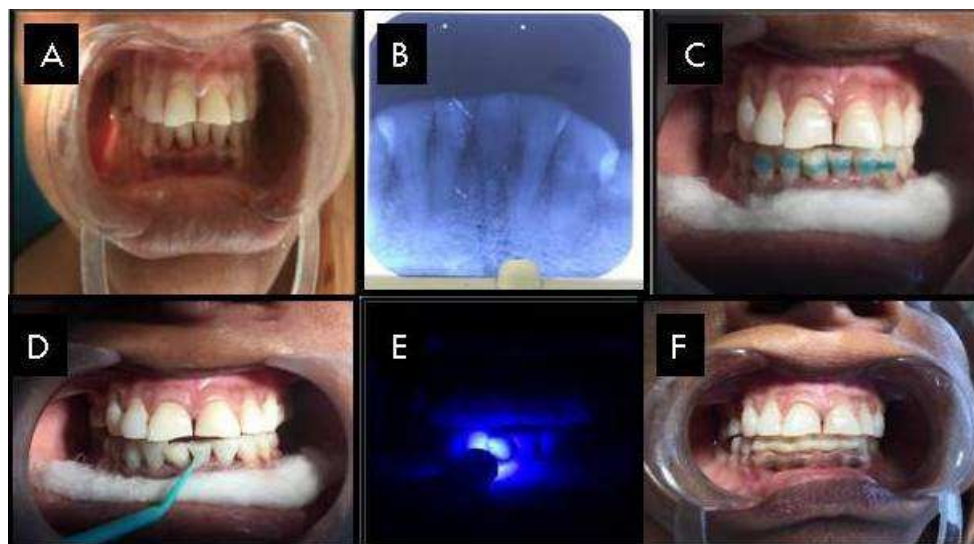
A- Intraoral view; B- Diagnostic radiograph; C- Acid etching with 37% phosphoric acid; D- Application of resin adhesive; E- Light cure; F- Finishing and polishing.
